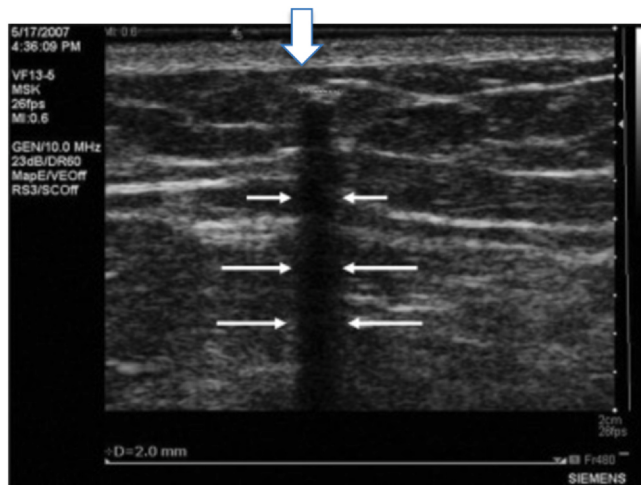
Transverse ultrasonographic image through the implant. The implant appears as a hyperechoic structure (bold arrow) and is distinguished from surrounding anatomical structures by a sharp posterior acoustic shadow (narrow arrows) on the transverse scan [59]. Reprinted from Gurel, Kamil, Kaan Gideroglu, Ata Topcuoglu, Safiye Gurel, Ibrahim Saglam, and Sukru Yazar. 2012. "Detection and Localization of a Nonpalpable Subdermal Contraceptive Implant Using Ultrasonography: A Case Report." *Journal of Medical Ultrasound* 20 (1): 47–49. <https://doi.org/10.1016/j.jmu.2012.01.005>.
